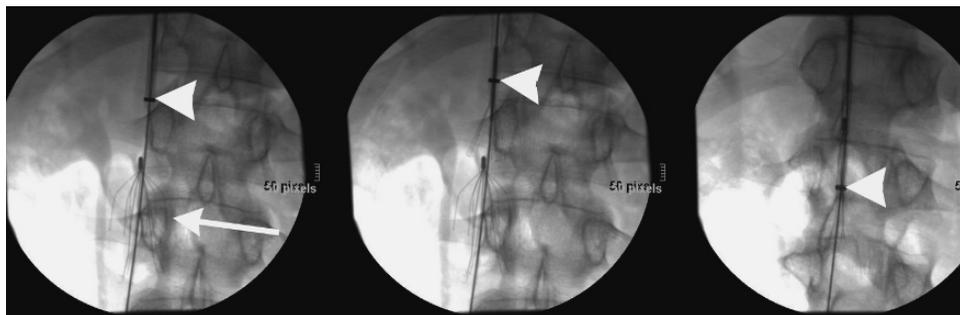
This patient had extensive DVT, proven PTE by CT, and spinal trauma precluding anticoagulation. A retrievable IFC filter (arrow) had been placed. A sheath (arrowhead) has been advanced through a right internal jugular approach, and is advanced to subsequently remove the filter.
